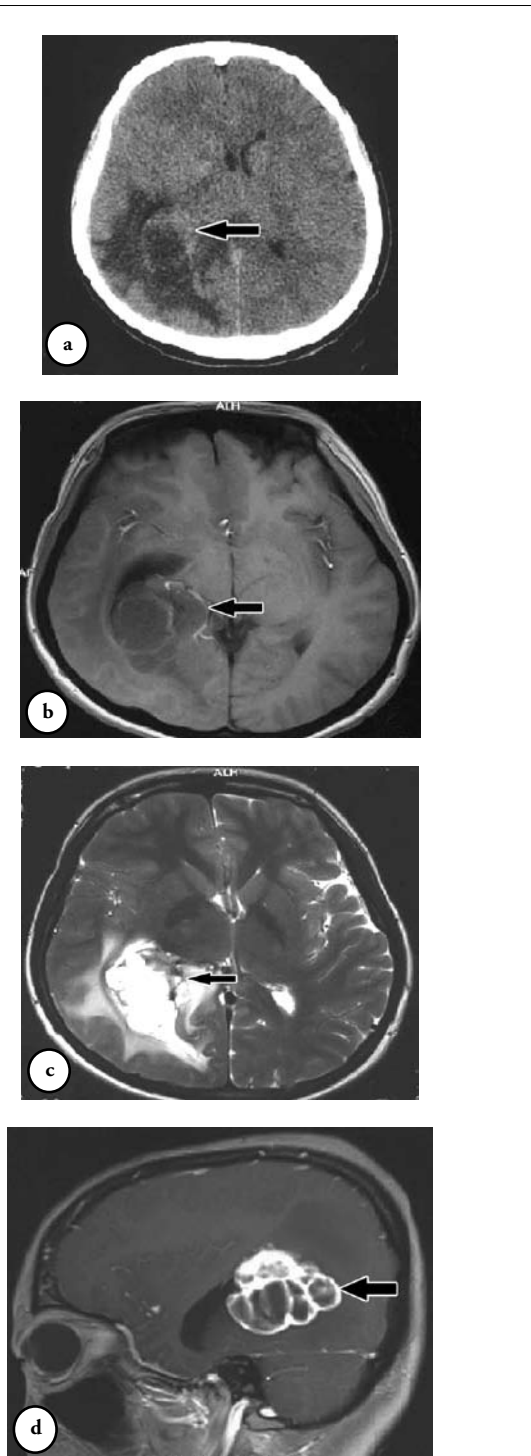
Pre-operative CT and MRI examinations showing a) non-contrast axial plain CT scan shows an isodense cystic-solid lesion in the right temporal lobe (arrow), which involves the right lateral ventricle (figures b, c, and d). The solid part of the lesion is hypointense on axial T1 imaging b), and hyperintense on T2 imaging c) (arrow). The solid part of the lesion is significantly enhanced (arrow), while the cystic compartments are not on the sagittal gadolinium-enhanced T1-weighted image d).
